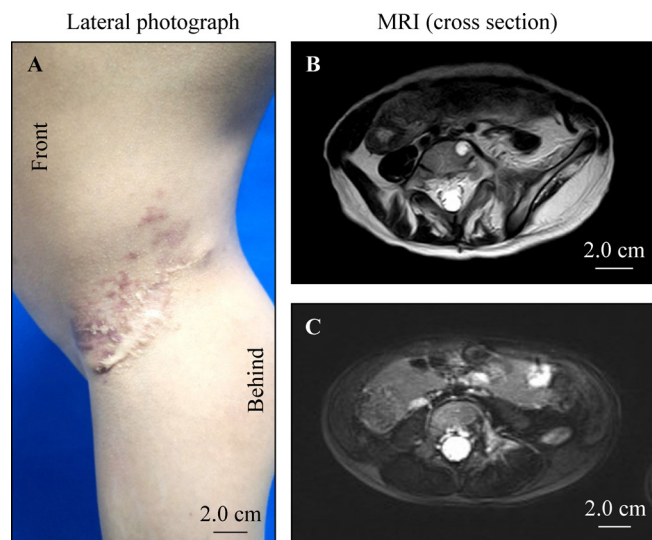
Case presentation of Cobb syndrome with Kaposi hemangioendothelioma/tufted angioma (KHE/TA). (A) patient presented with erythema surrounding the surgical incision on the left waist. (B) Preoperative MRI showed multiple abnormal signals in the left iliac, the left pedicle, transverse process and vertebral body of L2-S3 spine, as well as hyperplasia masses involving the left lower abdomen, soft tissue surrounding the left psoas major muscle and the left lumbosacral vertebral body. (C) Repeat MRI was performed 6 months into sirolimus therapy and revealed dramatic decreased of the dermis and near resolution of muscular invasion. KHE, Kaposi hemangioendothelioma; MRI, Magnetic resonance imaging; TA, tufted angioma.
